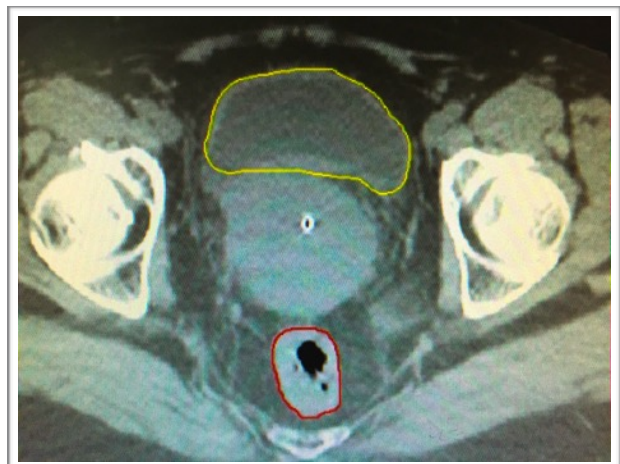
Transverse CT images showing central applicator in the uterus and rectum and bladder contours. Figure 1a shows organ wall contours, it can be seen that especially the rectum wall is not clearly visible on CT images and is time consuming to delineate. The bladder wall is easier to identify but it becomes more challenging when the bladder is empty. Figure 1b shows the external organ contour only. This approach is less time consuming and leaves less room for uncertainty regarding the extent of the organ.
